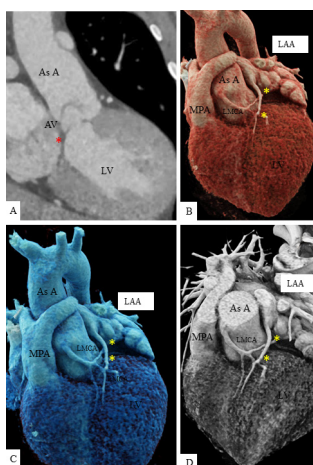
(A) Oblique coronal CT angiography (CTA) maximum intensity projection image shows hypodense thin membrane (red asterisk) below the aortic valve (AV). (B–D) Cinematic volume rendered images show that the main pulmonary artery (MPA) is anterior to ascending aorta (As A) (Lecompte manoeuvre—postarterial switch operation status) and anterior interventricular part of great cardiac vein (yellow asterisk) is draining into the left atrial appendage (LAA).
